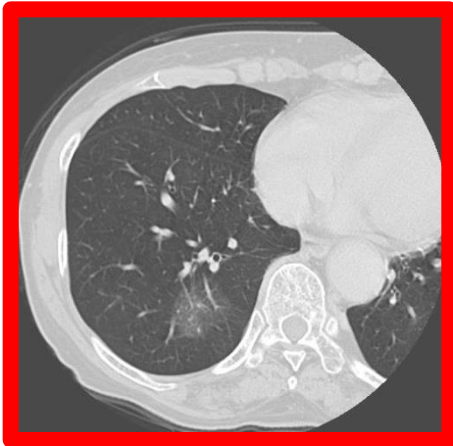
Calculation of the C/T ratio to define radiologic noninvasive lung cancer on TSCT. The maximum diameter of consolidation (C) is divided by the maximum tumor diameter (T) to give the C/T ratio. GGO, Ground-glass opacity; C/T, consolidation/tumor; TSCT, thin-section computed tomography.
